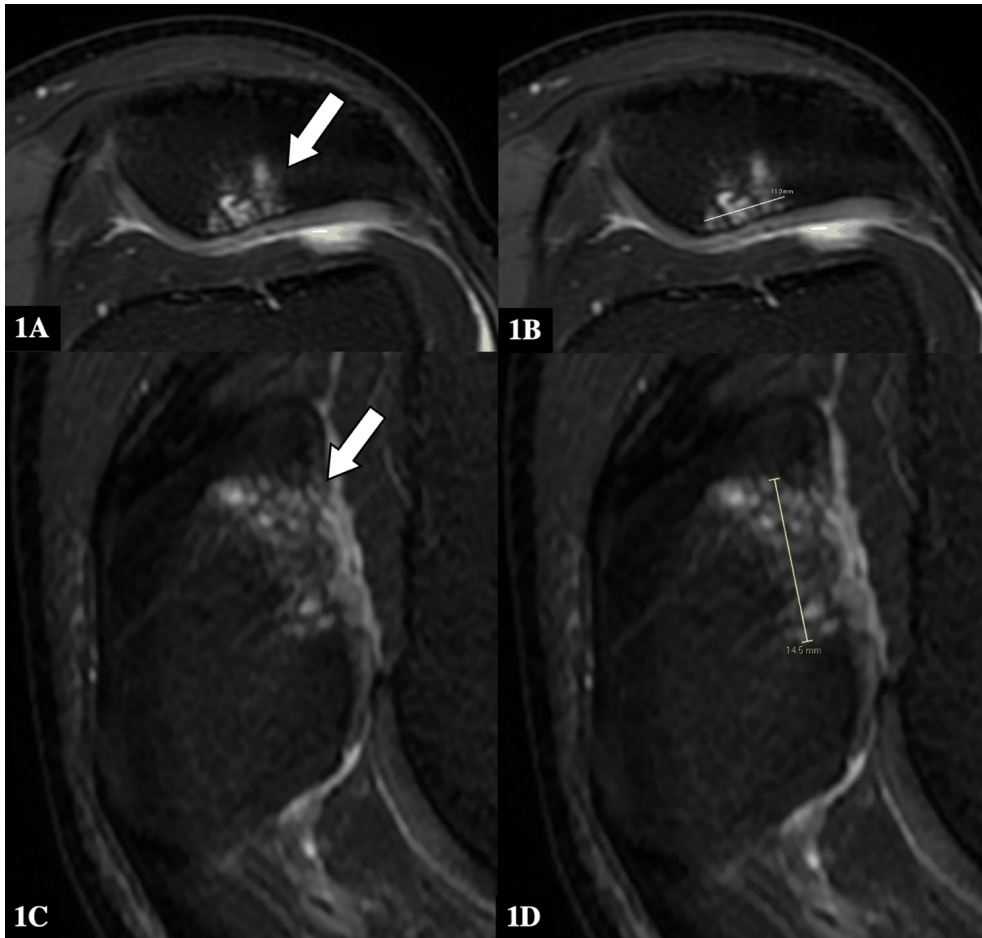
58-year-old male with a patellar chondral defect. FINDINGS: Pre-operative unenhanced MRI of the left knee demonstrates a 1.5 x 1.1 cm partial to full thickness chondral defect (arrow) in the patellar ridge with subchondral cysts and bone marrow edema. TECHNIQUE: 1a, 1b) Axial proton density fast spin echo fat suppression sequence on 3T. 1c, 1d) Sagittal oblique T2-weighted fat suppression sequence on 3T.
